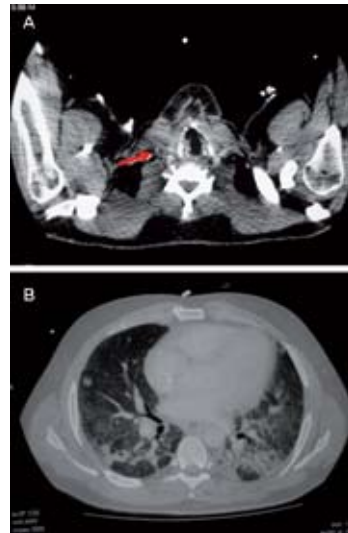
A. Contrast enhanced CT showing thrombus at right internal jugular vein (arrow). B. Contrast enhanced CT showing septic pulmonary emboli with cavitations and pleural effusion.
